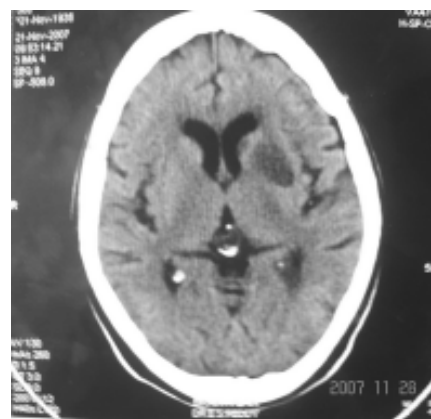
CT scan brain showing acute infarct in left capsulo ganglionic region.
